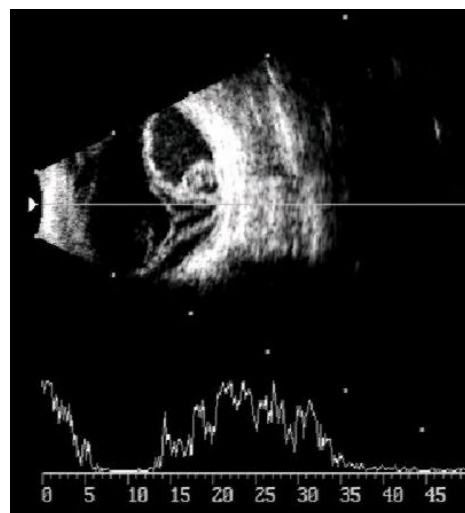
A and B scan ultrasound of serous choroidal detachment
